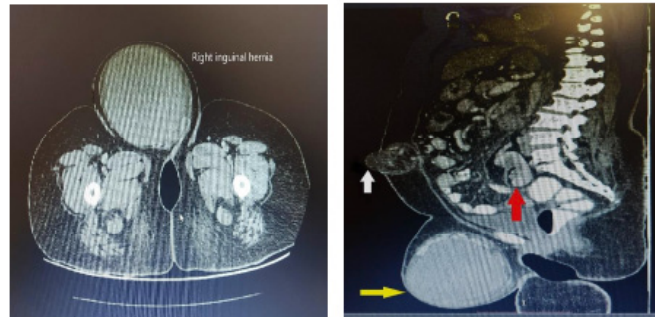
(left): Axial view of computerized tomography (CT) scan showing right inguinal hernia. Fig. 2b (right): Sagittal view of CT scan showing right inguinal hernia containing ovarian tumour (yellow arrow) and umbilical hernia (white arrow); right ectopic kidney noted (red arrow)
